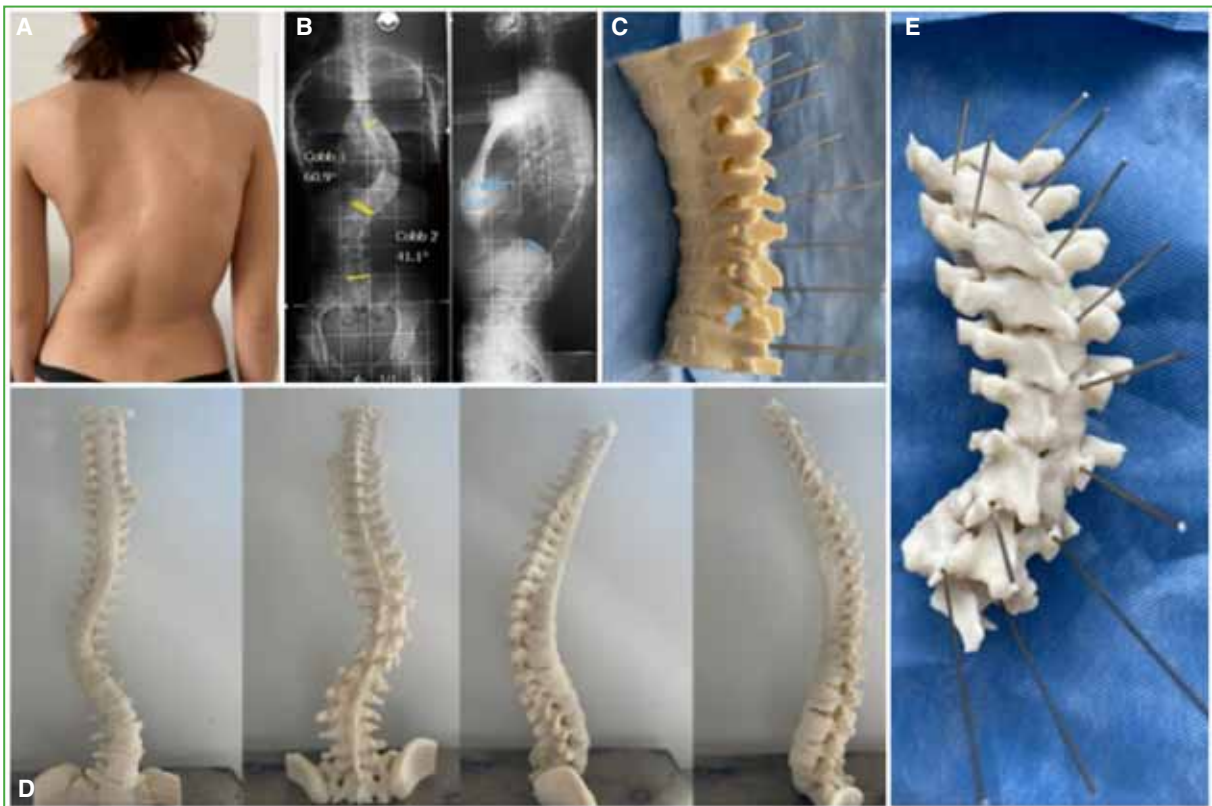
Clinical case 4. A. Clinical image of the patient with idiopathic scoliosis. B. AP and lateral radiographs of the spine. C. 3D printed model. D. Radiographic control in the immediate postoperative period. E. Clinical image 21 days after surgery.
